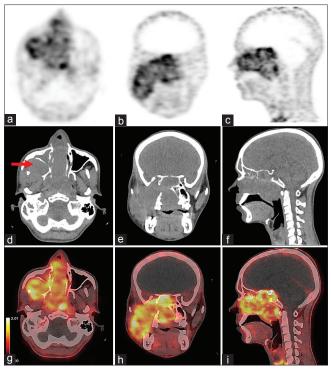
DOTANOC scan revealing heterogeneously increased tracer uptake in the tumor along with characteristic anterior bowing of posterior wall of the maxilla ("Holman miller antral bowing sign", arrow) (a). In addition, the intracranial extent of the tumor could be clearly demarcated as there was no uptake in the brain, except for pituitary gland – axial, coronal, and sagittal PET (a-c), CT (d-f), fused PET/CT images (g-i), respectively
